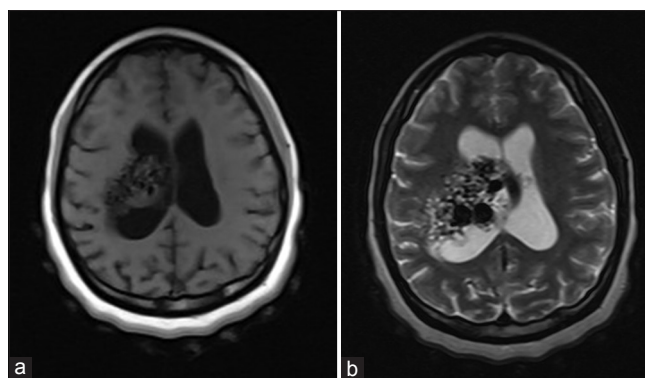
(a and b) Magnetic resonance imaging of the brain in a 17-year-old female with seizures. Axial T1- and T2-weighted sequences demonstrate a complex right subependymal mass with oval signal void areas due to a nidus of tortuous vessels
